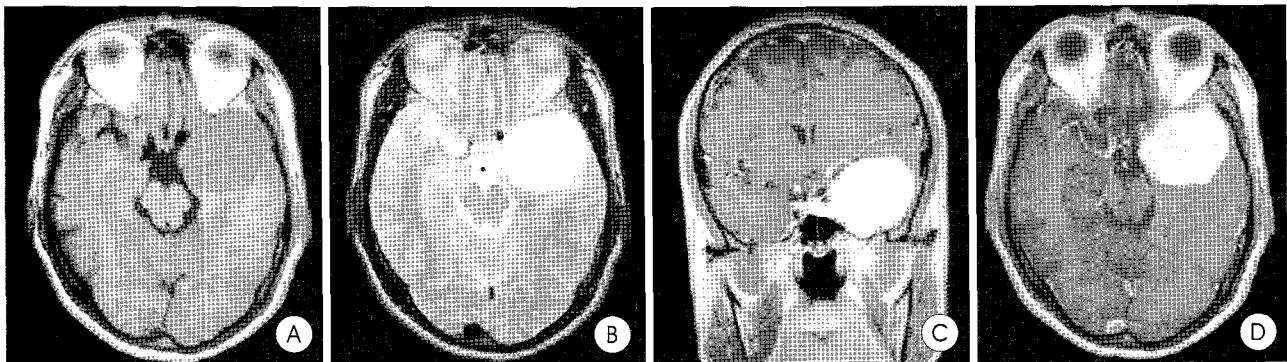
Preoperative magnetic resonance image(MRI) (A : T1WI, B : T2 WI, C : Coronal image with enhancement, D : Axial image with enhancement) MRI revealing a large tumor in the left cavernous sinus, extending into the middle cranial fossa, with bright enhancement and a well defined margin. T2-weighted image showing that the tumor exhibited marked hyperintensity that is similar to that of cerebrospinal fluid.
